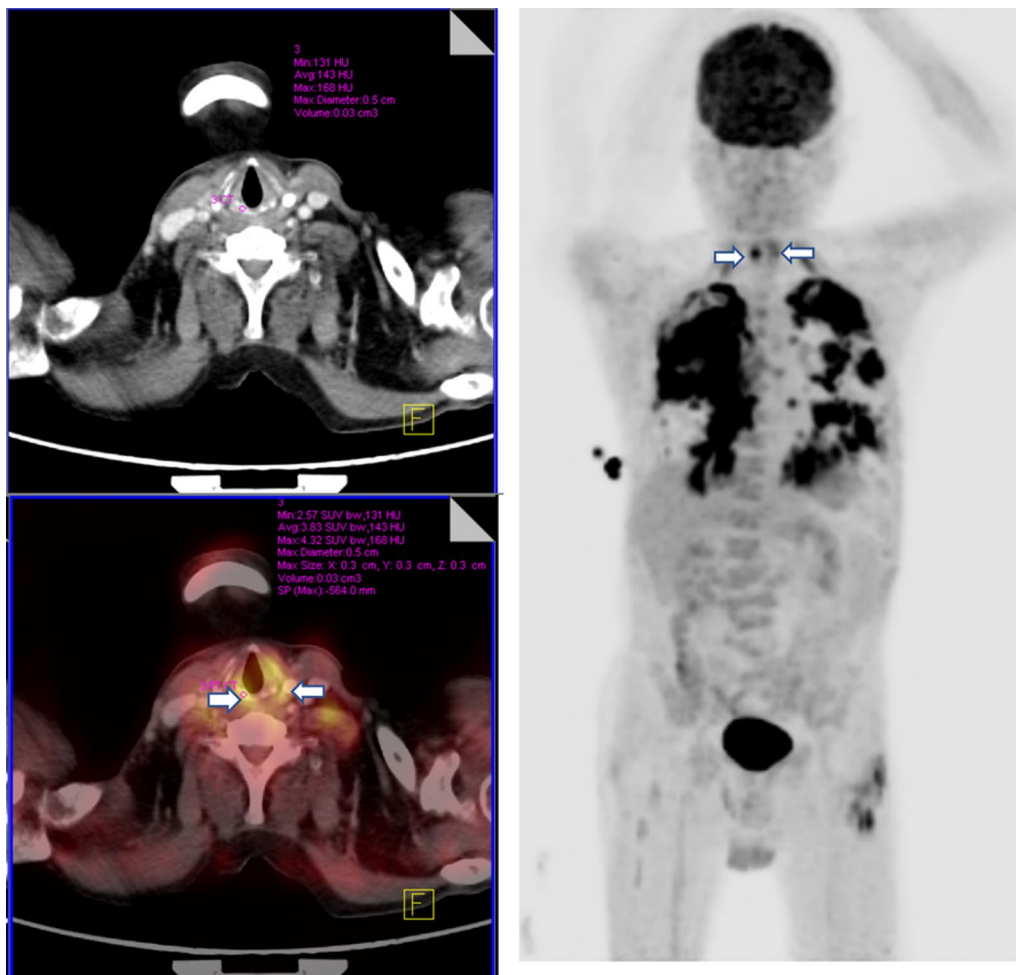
Axial PET/CT demonstrates bilateral increased FDG uptake of the vocal cords (arrows) with thickened cords and pericordal fat stranding on CT, most compatible with chronic inflammatory reaction from prolonged coughing and active pulmonary tuberculosis
